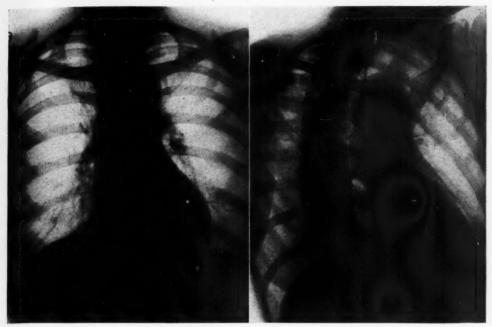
and 3b (108373). Roentgenograms of a orta in second position: (a) anterior-posterior view; (b) oblique view.
